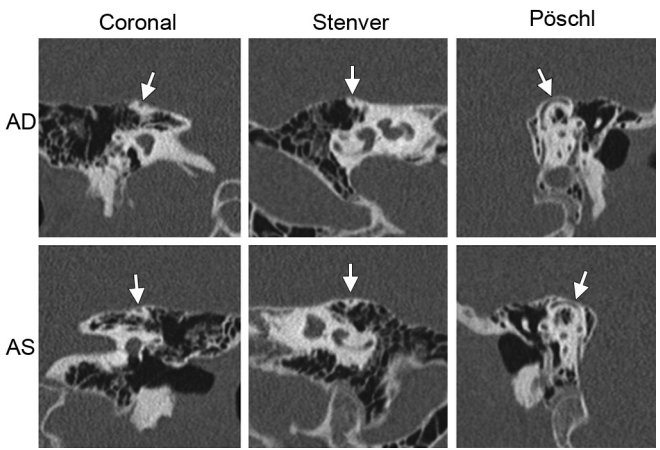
Case 1. High-resolution computed tomography (CT). AD, right ear; AS, left ear. All views (coronal, Stenver, and Pöschl) show thinning of the arcuate eminence (peak) of the superior canals bilaterally (arrows), but no clear dehiscence. The tegmen is intact without evidence of dural herniation on either side, and mastoids are well aerated bilaterally.
